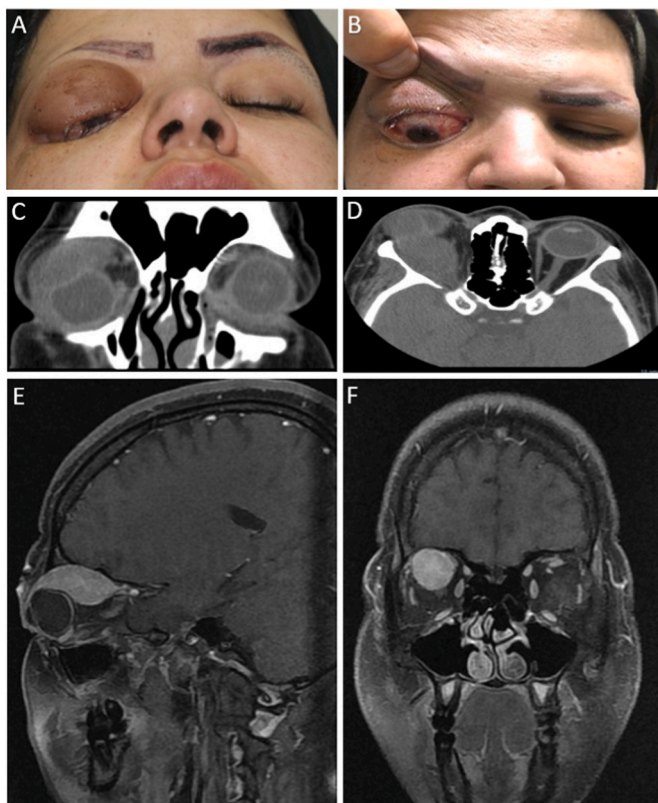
A and B, External photographs of a 25-year-old woman showing severe eyelid swelling, ptosis, proptosis, downward displacement of the globe, and injection. C, Coronal orbital computed tomography (CT) scan showing isodense superior mass with globe indentation. D, Axial orbital CT scan showing the mass inside the superior rectus muscle throughout its length to apex and exhibiting optic nerve compression. E, Sagittal T1-weighted Fat Sat magnetic resonance imaging (MRI) contrast image showing hyperintense fusiform mass lesion of the superior rectus muscle sparing the origin and insertion. F, Coronal T1-weighted Fat Sat MRI contrast image showing the orbital mass with no cerebral or sinuses extension.
